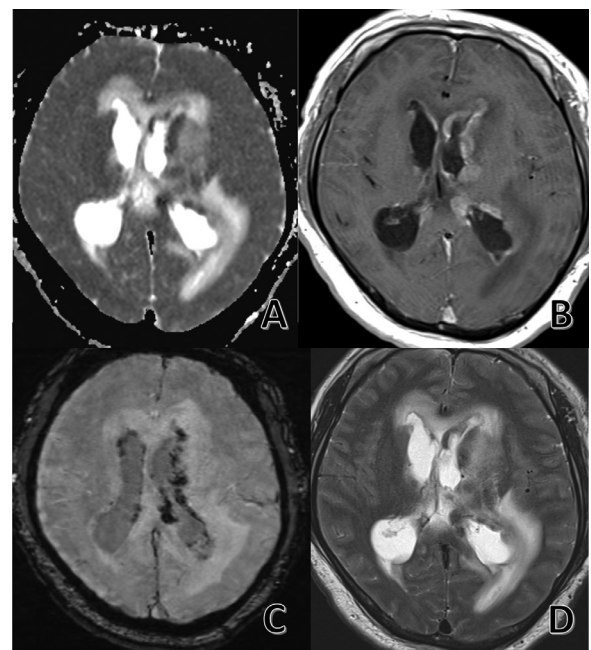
Preoperative MRI 5-days after the initial scan revealed progression of the lesions (A, B) with increased haemorrhage (C) and greater mass effect and cerebral oedema (D).
